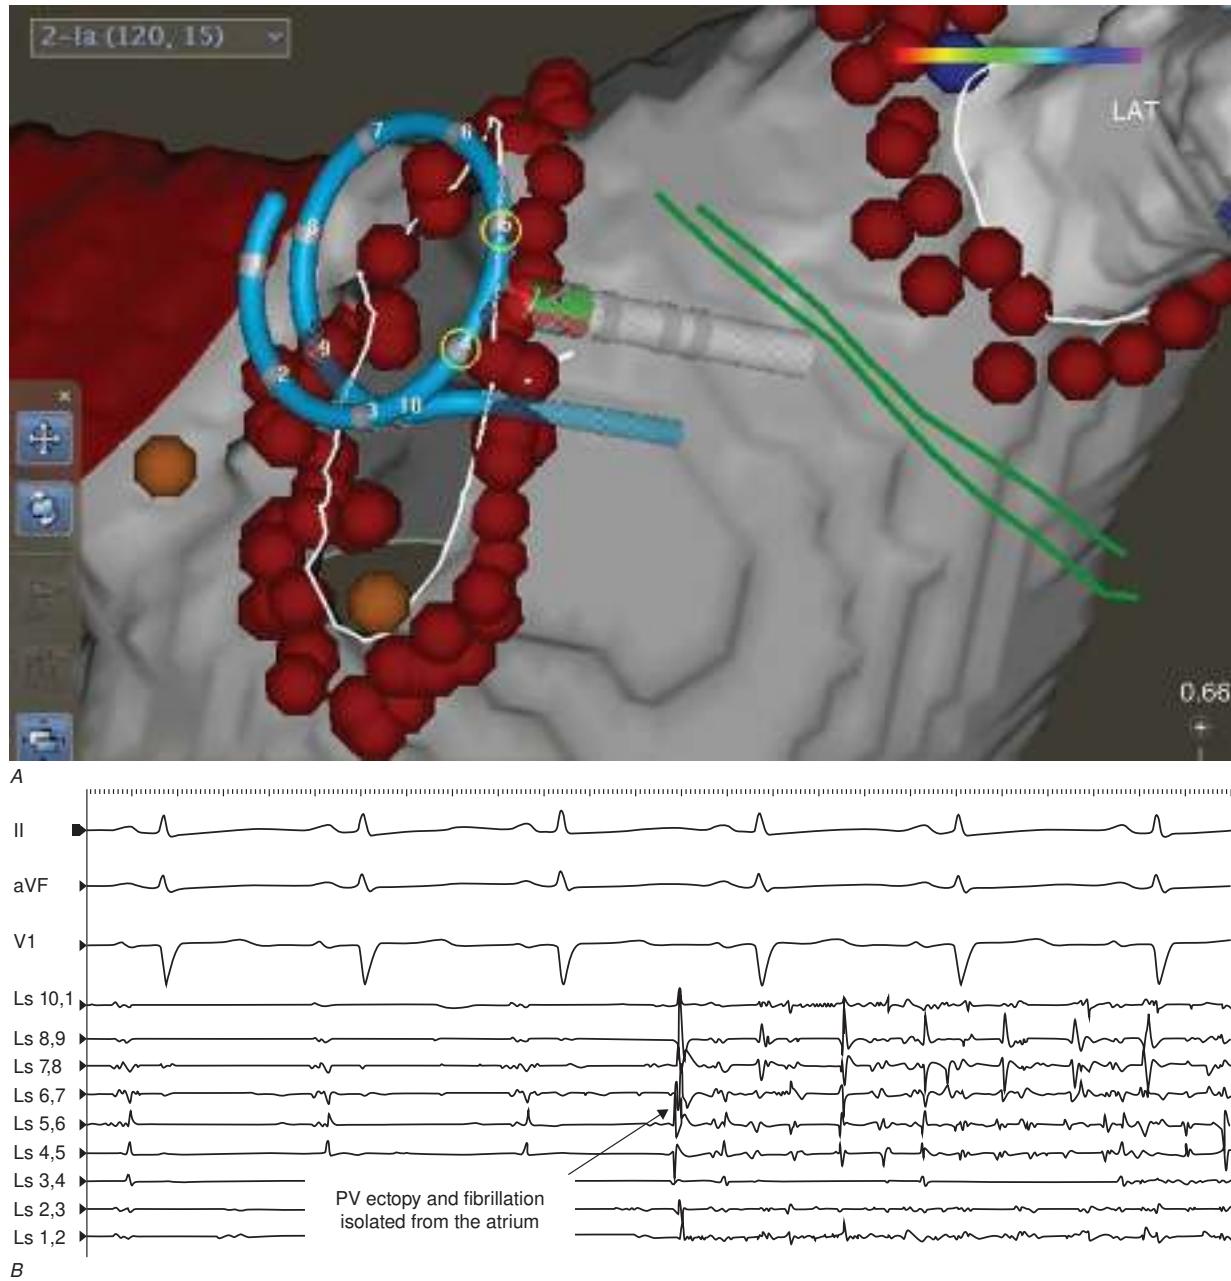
A. Electroanatomic map superimposed on an MRI reconstruction of a left atrium with mapping catheter in the left common pulmonary vein and ablation catheter at the pulmonary vein-left atrium junction. B. Spontaneous pulmonary vein (PV) ectopy initiating fibrillatory conduction contained within the isolated vein.
